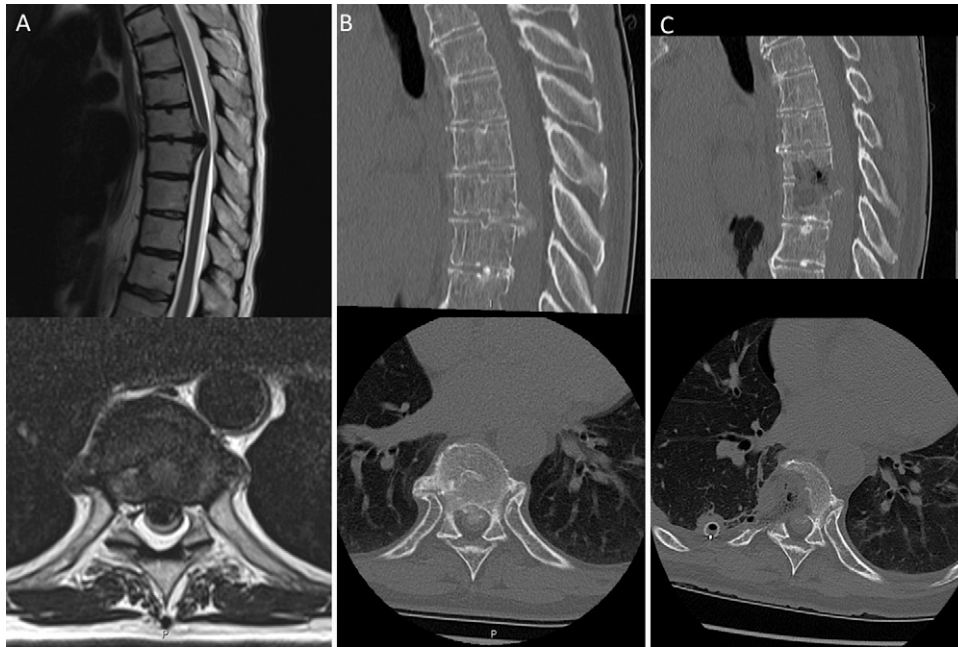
Case 3. A: Preoperative sagittal (*upper*) and axial (*lower*) T2-weighted MRI shows a large central disc prolapse with marked flattening of the spinal cord. B: Preoperative sagittal (*upper*) and axial (*lower*) CT shows the calcified disc prolapse extending into the spinal canal and the calcification at the right costovertebral joint. C: Postoperative sagittal (*upper*) and axial (*lower*) CT shows removal of the head of the rib, pedicle and vertebral body on the right side; the shell of mobilized calcification at the posterior margin of the thecal sac can also be seen.
